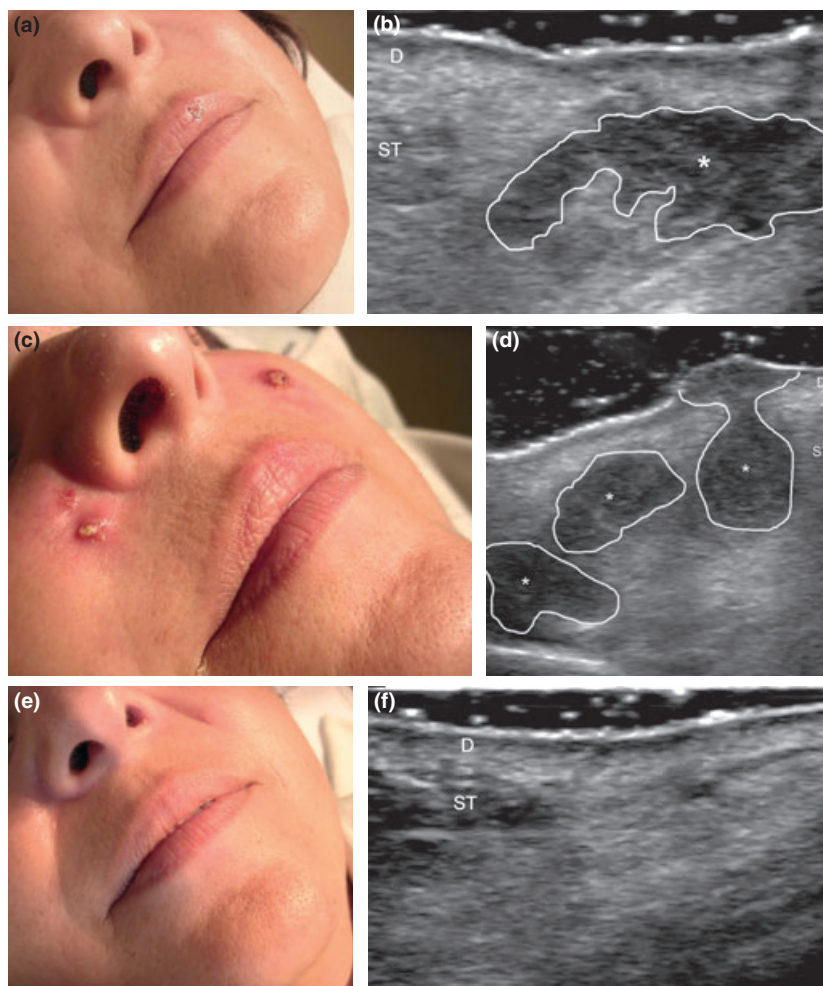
Filler dermatopathy after injection of hyaluronic acid-lidocaine: (a) One month after injection, nasofold nodules, erythema and oedema and inflammatory lesion in the upper lip. (b) Ultrasound (transverse views): hypoechoic pseudocyst (*) with inner echoes (debris) in the subcutaneous tissue. (c) Clinical worsening at 6 weeks after injection. (d) Ultrasound (transverse view): further dispersion of the filler; several of the hypoechoic pseudocysts now contain more debris and one of them is open. (e) Clinical resolution at 6 months. (f) Ultrasound image is normal (transverse view). D, dermis; ST, subcutaneous tissue.
